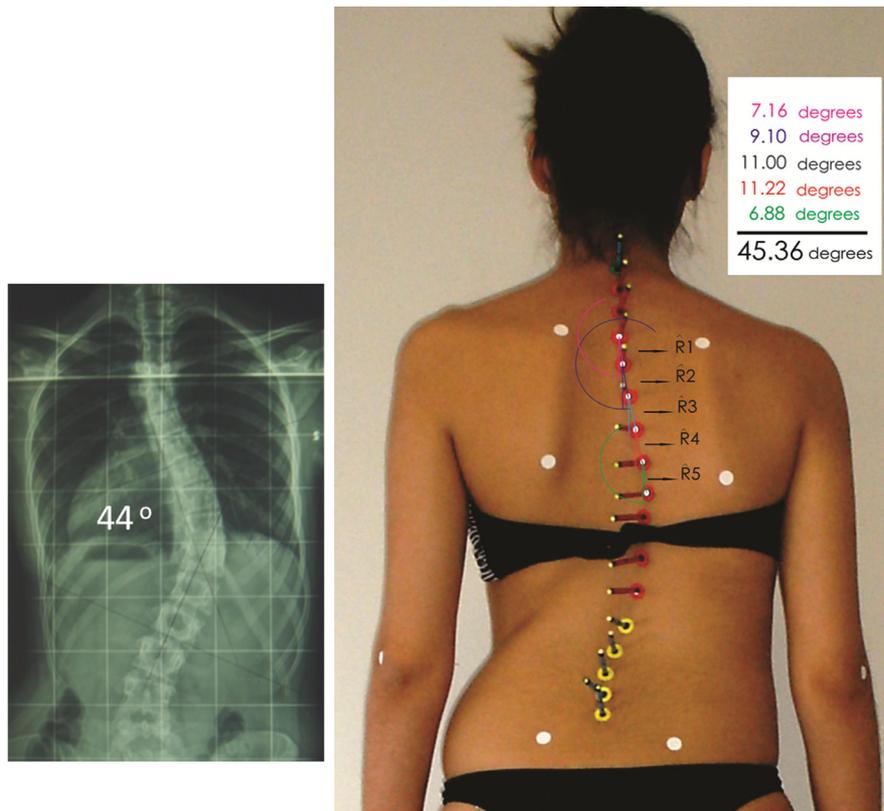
Measurement of scoliotic curve through photogrammetry and radiography in a patient included in the study sample. Photogrammetric method: Step 1—measurement of Rn angles for each segment localized between the superior limit vertebra and the apical vertebra: R1=7.16°, R2=9.10°, R3=11°, R4=11.22°, R5=6.88°. Step 2—sum of Rn angles=final MR angle=45.36 degrees. Radiographic method: measurement of the Cobb angle was 44° for the same patient.
